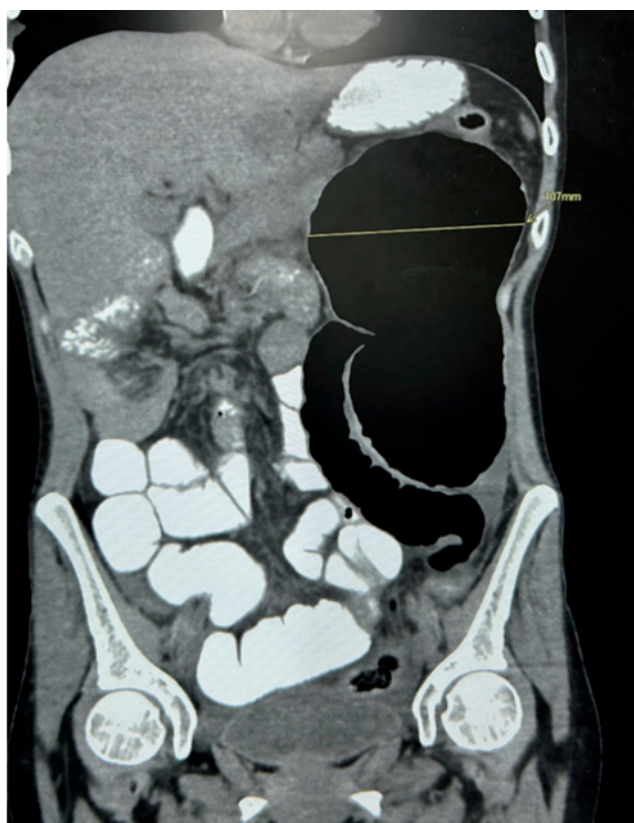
CT-scan showed marked distension of the cecum measuring about 11 cm with counterclockwise twist consistent with a type 2 cecal volvulus.
